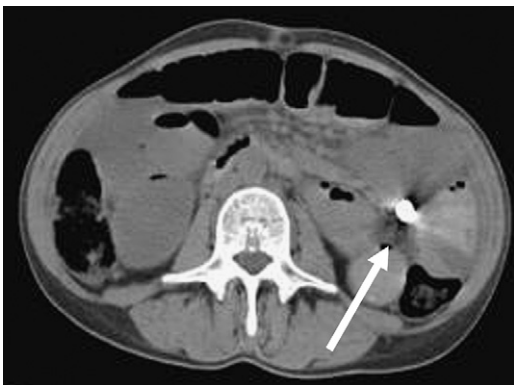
Retained capsule. CT demonstrates a high-density metallic artifact (arrow) in the left upper quadrant in a patient who recently underwent capsule endoscopy. After 4 days, the capsule did not pass.
